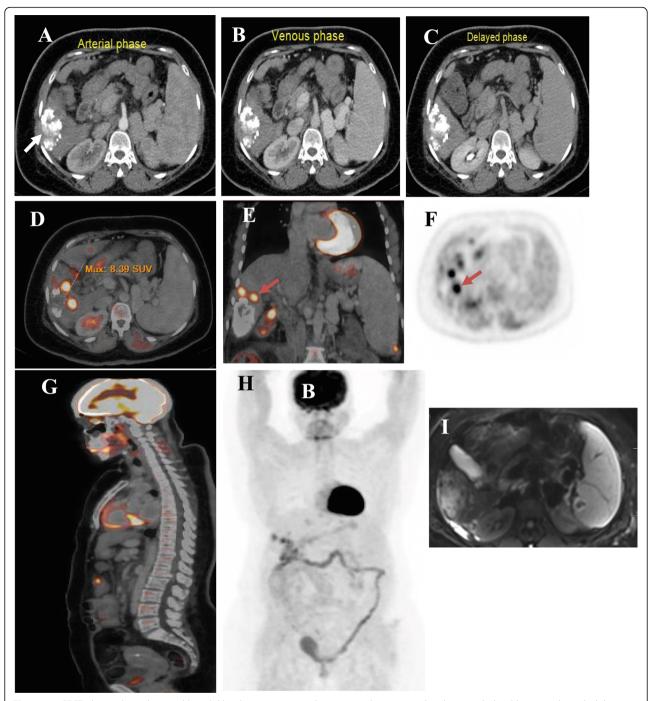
a–c CECT phases show dispersed lipiodol hindering contrast enhancement detection at the chemoembolized lesion at the right lobe (arrow). d and e Fused PET/CT images show two hyper metabolic focal uptakes at the superior aspect of the chemoembolized lesion(red arrow). f Axial CTAC image showing the two focal FDG uptakes around photopenic center(red arrow). g sagittal fused PET/CT whole spine shows no vertebral osseous deposits. h 3D CTAC summarizing the whole study
